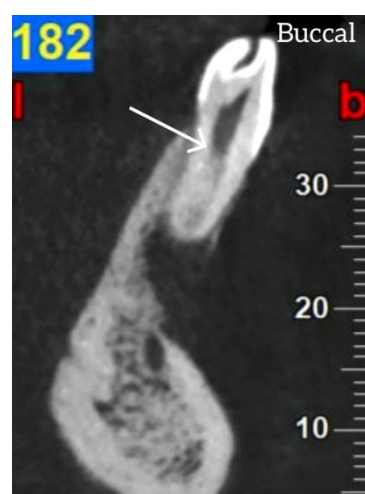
Cone beam computed tomography (CBCT) sagittal section of tooth #31 revealing Vertucci's Type III canal configuration, characterized by one canal leaving the pulp chamber, bifurcating within the root (white arrow), and merging apically into a single canal
